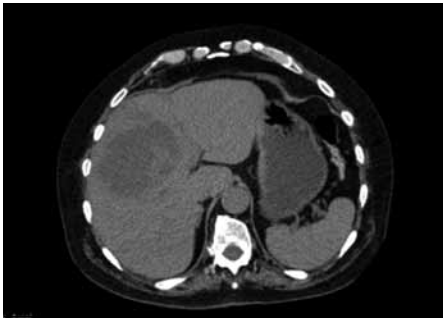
Computed tomography scan at presentation showing a large lobulated low attenuation area in the liver, 10 cm in maximum diameter, lying close to the diaphragmatic surface in the right lobe.
